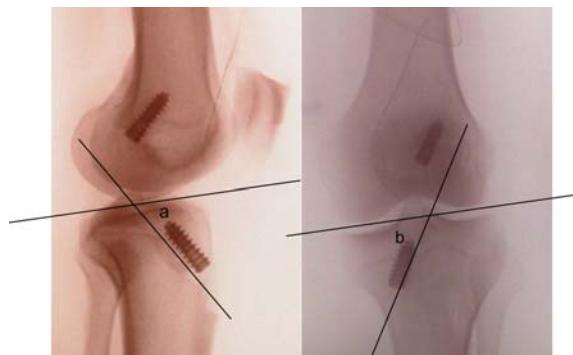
Sagittal angle (a) and coronal angle (b) of the postoperative radiographs
